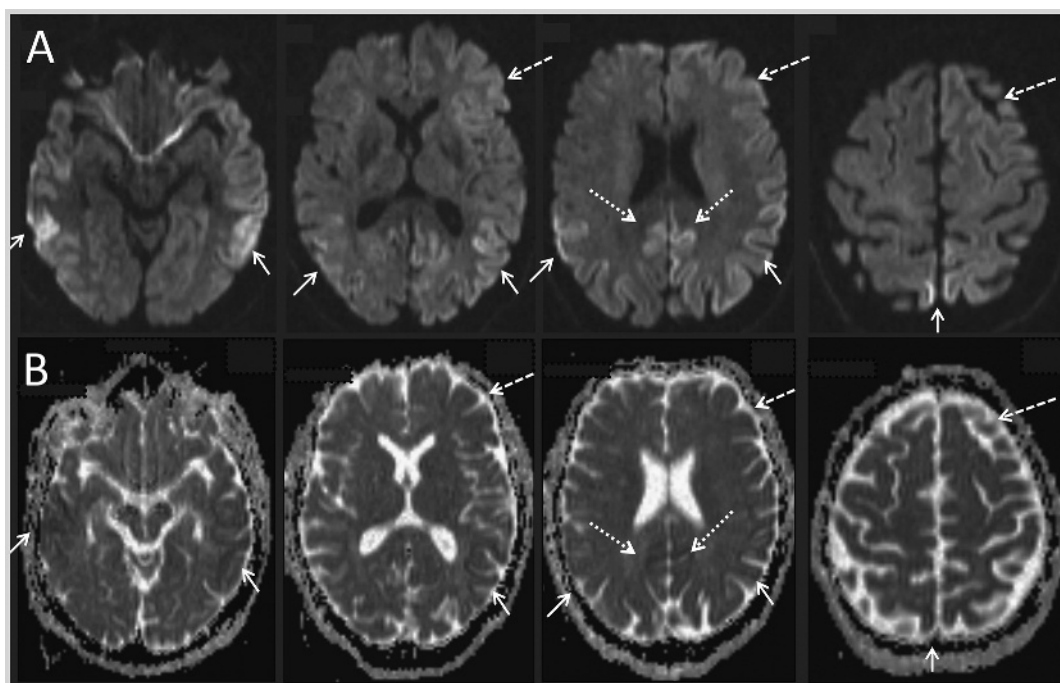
Imaging of the patient in Case 4-1. *A*, Axial diffusion-weighted imaging (DWI) and *B*, axial apparent diffusion coefficient (ADC) map 3 months after onset of sporadic Jakob-Creutzfeldt disease. Bilateral restricted diffusion cortical ribboning is shown in the bilateral temporal (solid arrows), parietal (solid arrows), posterior cingulate (dotted arrows) cortices, and the left frontal cortex (dashed arrows).
